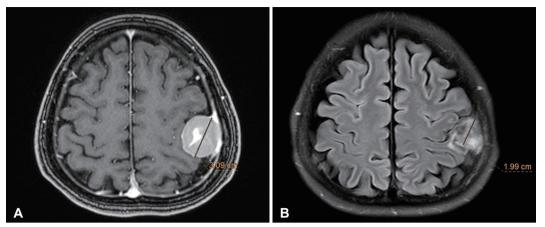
Initial MRI T1 contrast enhancement image of a 37-year-old woman complaining of nausea and vomiting shows a 19.6 cm³ meningioma in the left frontoparietal convexity (A). At 26.5 months after CyberKnife radiosurgery, the volume had decreased to 4.1 cm³ on the last MRI (B).
